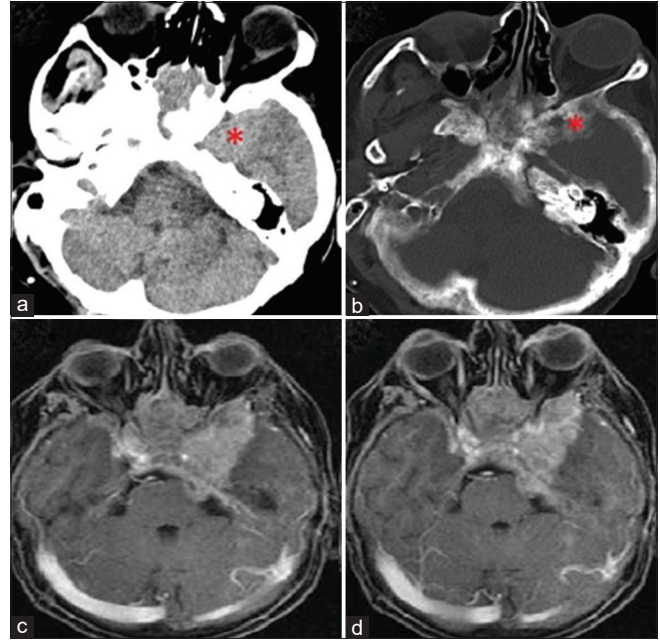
(a and b) Axial computed tomography scan showing a left temporobasal lesion with hypertrophic bone changes. (c and d) Axial postcontrast magnetic resonance imaging showing an extra-axial left temporobasal lesion with extension to the midline subfrontal region with poorly demarcated margins from the left temporal lobe.
